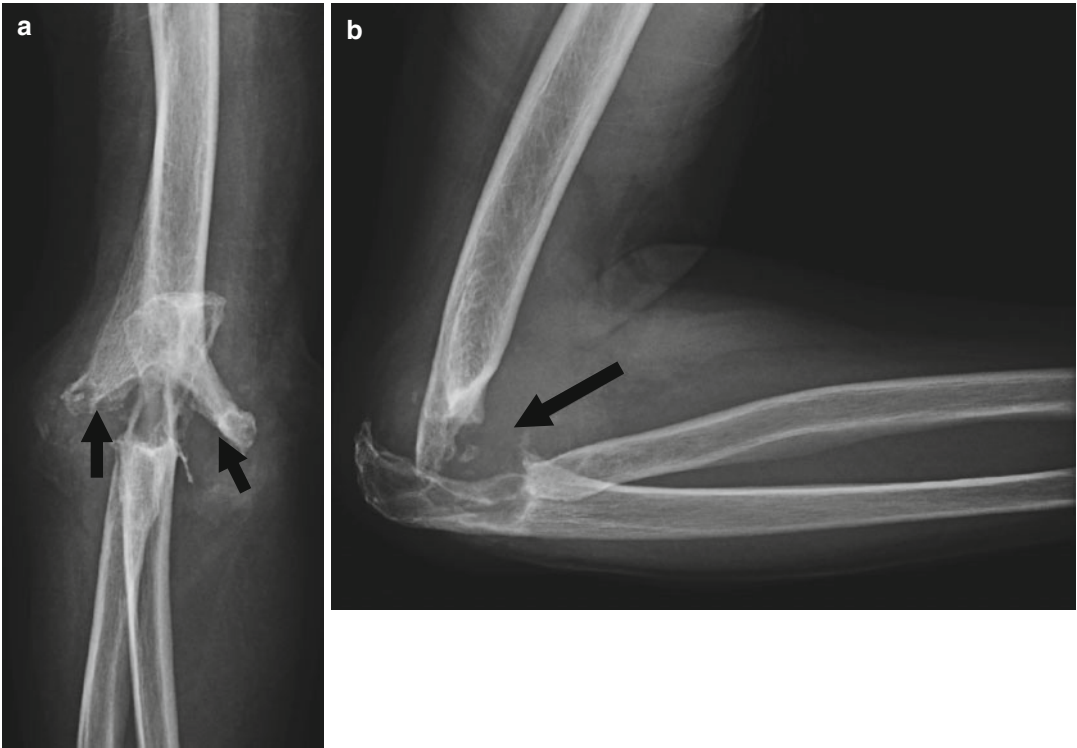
Anteroposterior (a) and lateral (b) lateral radiograph has to be turned 90° to the right, on the same way as a watch (arrows)
